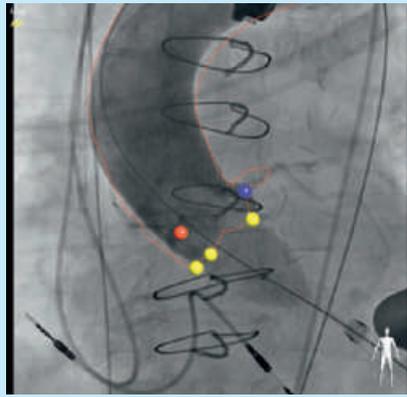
HeartNavigator overlay during balloon deployment. Red outline marks the aortic root derived from the CTA.
